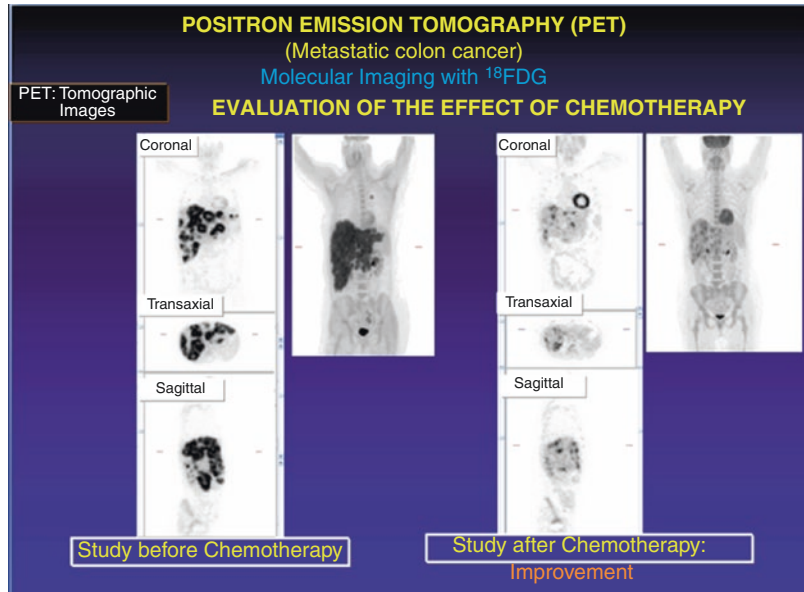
FDG-PET studies in metastatic colon cancer. The studies were performed before and after partially effective therapy of lesions in the liver and lungs
